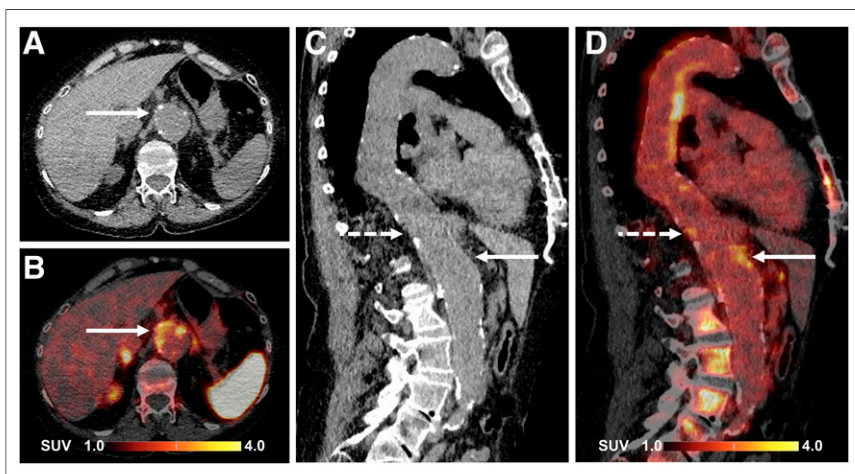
^{68}Ga -pentixafor PET/CT images of abdominal aorta in 64-y-old woman. CT (A and C) and PET/CT (B and D) images in transaxial (A and B) and sagittal (C and D) views show ^{68}Ga -pentixafor uptake in partly calcified atherosclerotic lesion (solid arrows) in wall of atherosclerotic ectatic aorta. Sagittal views show additional foci of uptake in non-CP (dashed arrows).
